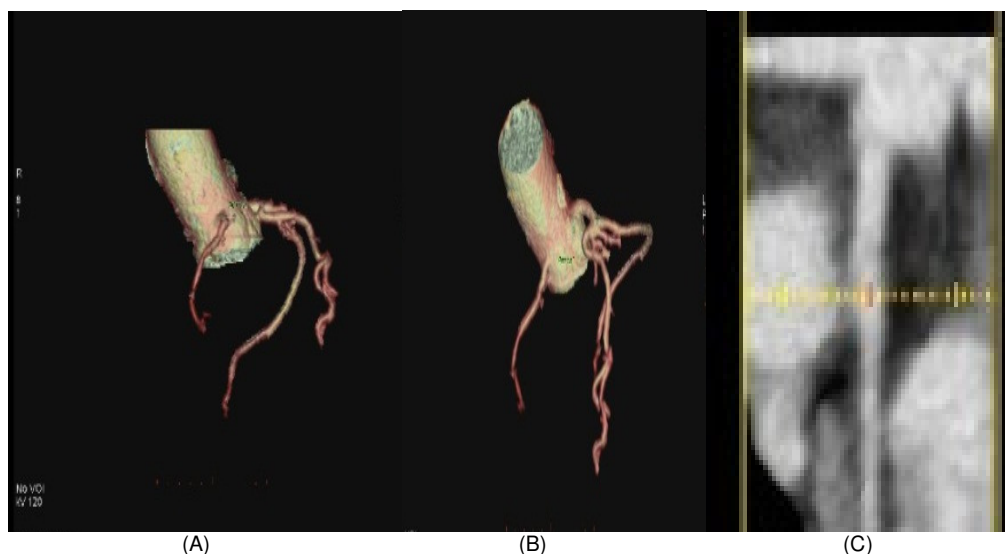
Shows Coronary CT angiography of (A,B) 3D volume rendering image, and (C) curved multiplanar reformatted (MPR) of Coronary calcium score is zero. Left main coronary artery anomaly was noted in the distal part which looked like aneurysmal dilatation with quadfurcation of the left main artery, left circumflex, ramus and left marginal artery.
